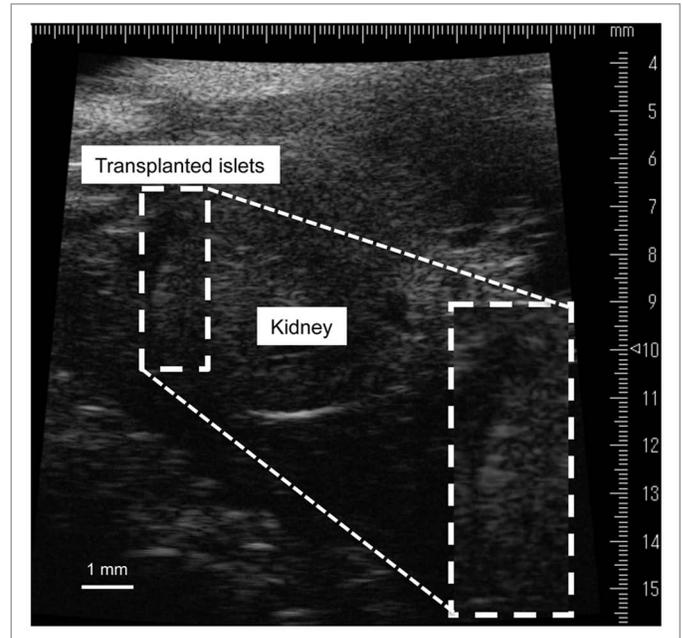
High-frequency ultrasonographic (HF-US) image of transplanted islets in the subrenal capsule. The islets appear as a hyperechoic area on the surface of the kidney. This is a modified version of a figure from a previous study.⁷⁵
